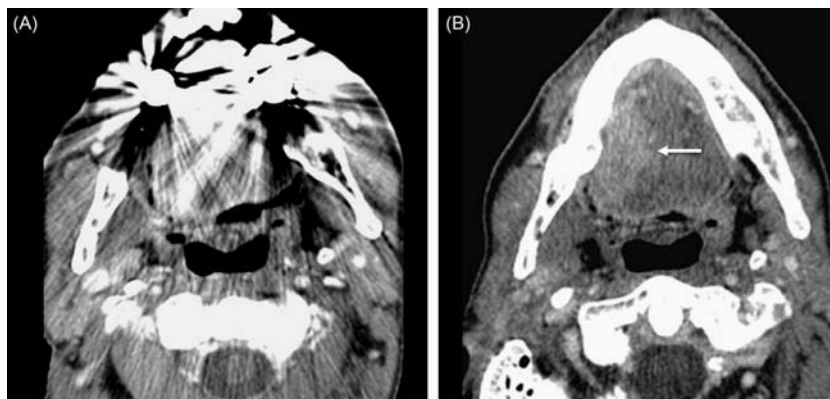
Usefulness of reangled images to visualize squamous cell carcinoma of the right oral tongue. (A) Axial CT through the oral cavity is non-diagnostic because of dental amalgam and extensive streak artifact. (B) Delayed and reangled axial contrast-enhanced CT image shows a large enhancing right oral tongue mass (arrow), effacing the right sublingual space. From Aiken, A. H. (2013). Pitfalls in the staging of cancer of oral cavity cancer. *Neuroimaging Clinics of North America* 23 (1), 27–45.
